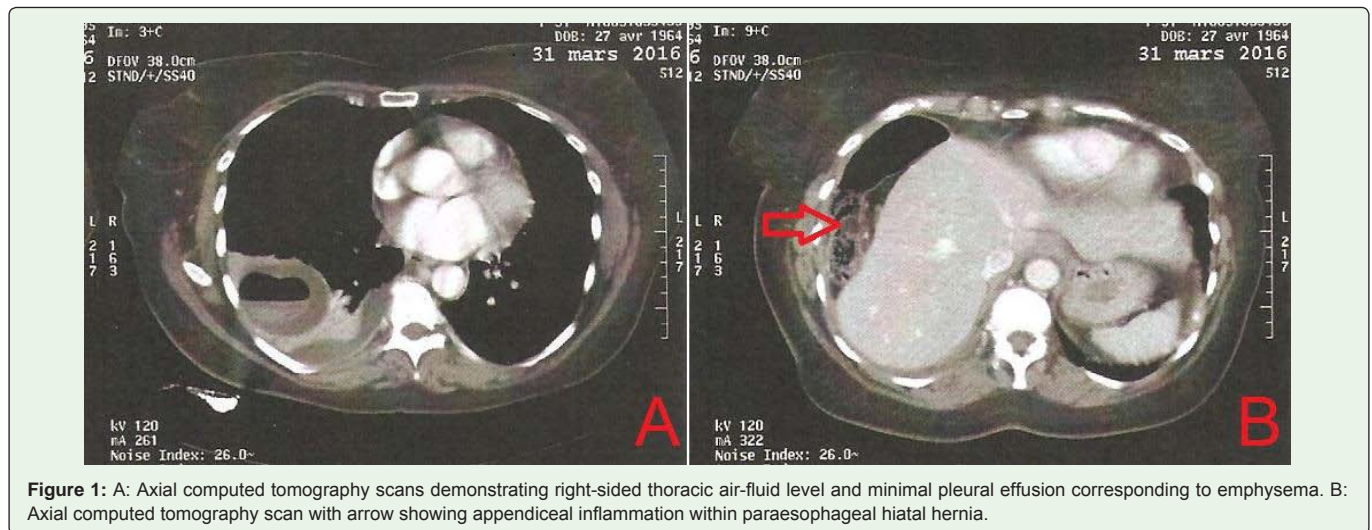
A: Axial computed tomography scans demonstrating right-sided thoracic air-fluid level and minimal pleural effusion corresponding to emphysema. B: Axial computed tomography scan with arrow showing appendiceal inflammation within paraesophageal hiatal hernia.
